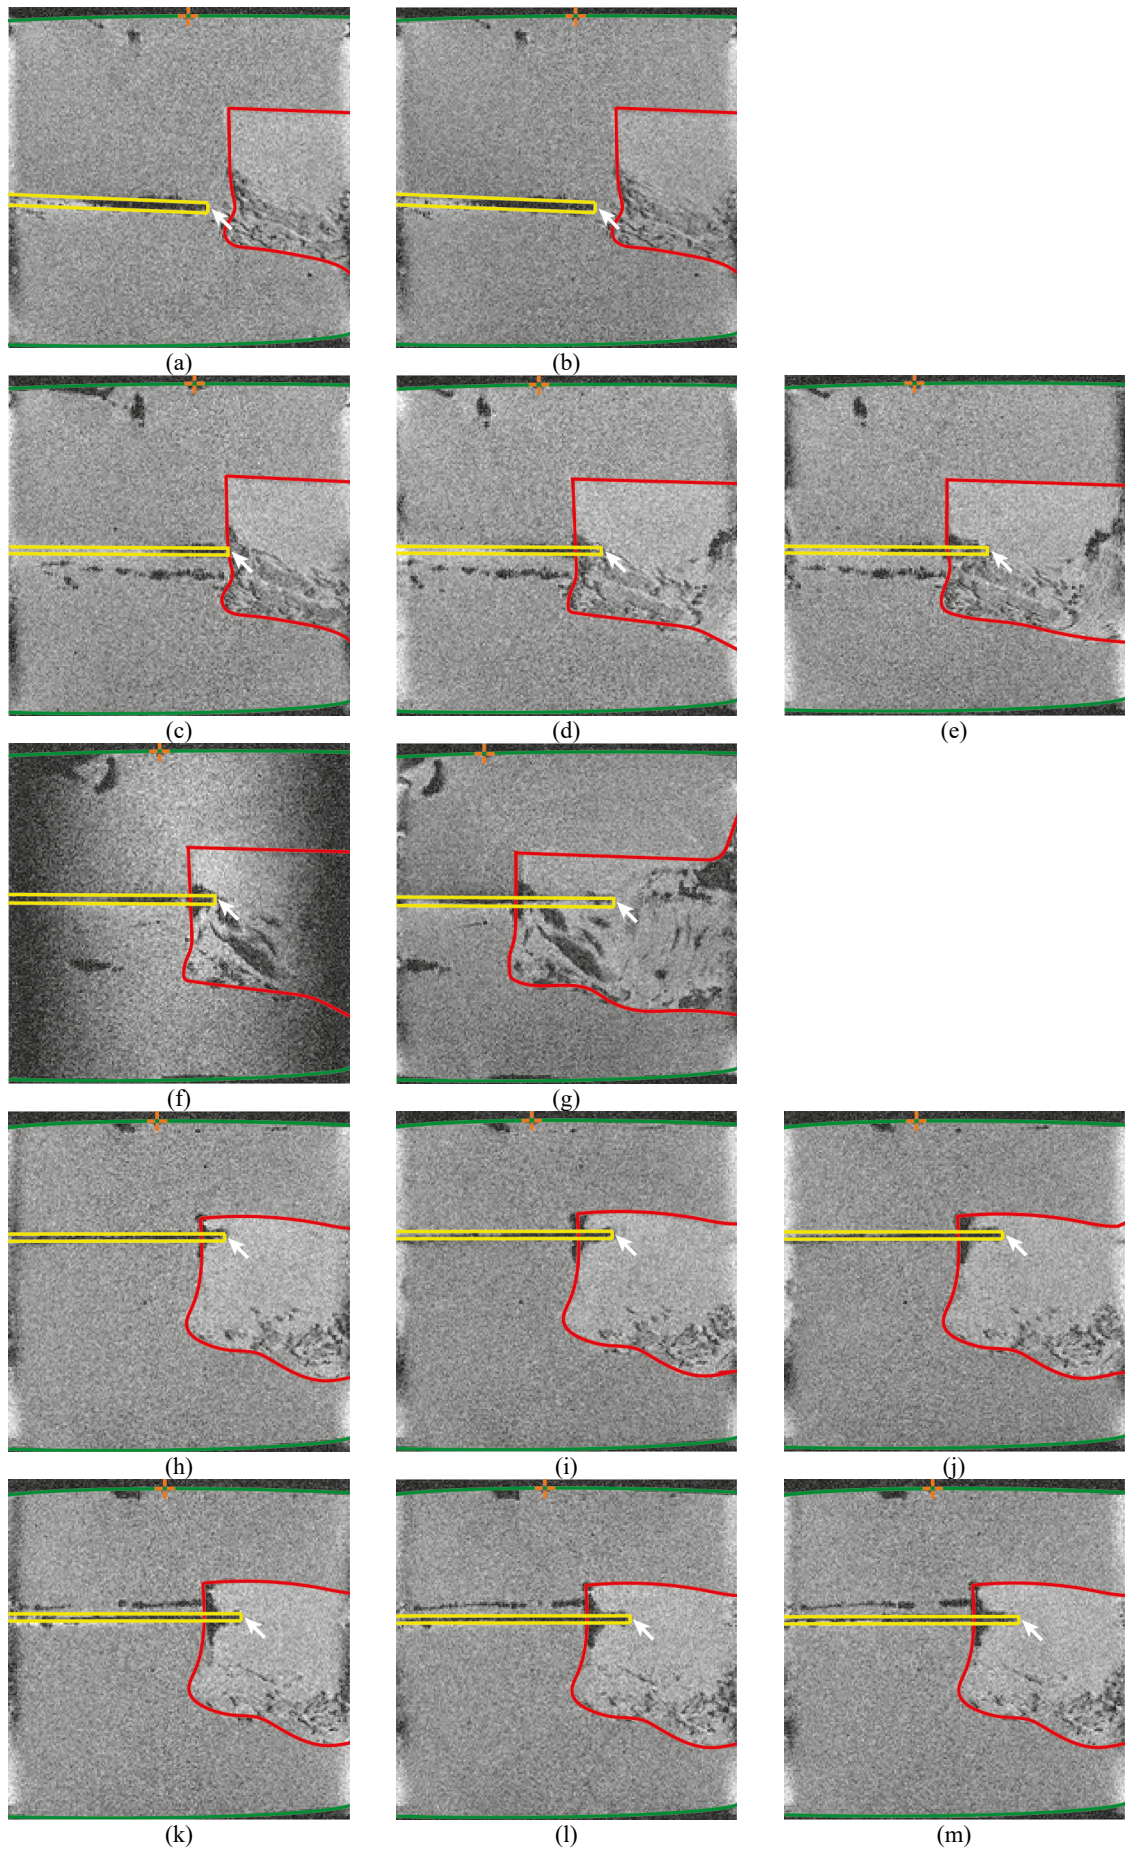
MR images of the needle inside the agar and *ex vivo* prostate tissue. Each row represents one measurement number. The first column shows the initial frame where the tip is positioned inside the agar in front of the prostate tissue. The second column shows the frame after actuation for five cycles. The third column shows the frame after the second actuation for five cycles. The yellow, red, and green contours show the needle, the prostate tissue, and the box sides, respectively. The arrow marks the needle tip. The orange crosshair shows the reference point in the side of the box that indicates a 40-mm insertion depth.
